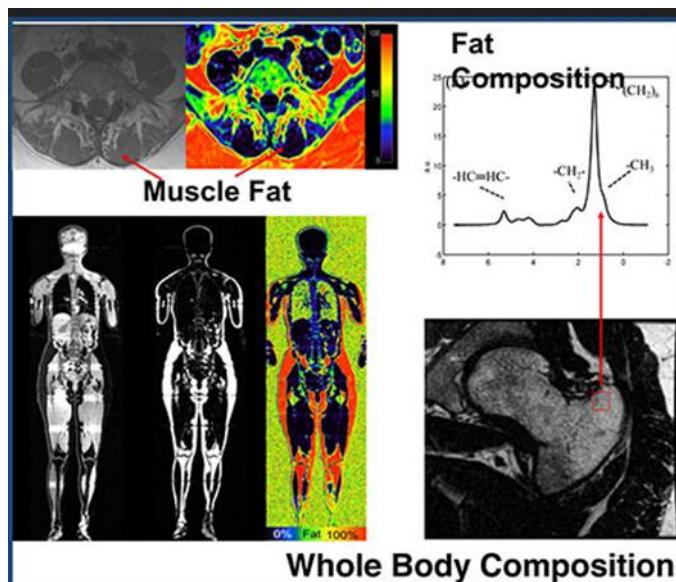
Whole body Dixon magnetic resonance imaging
